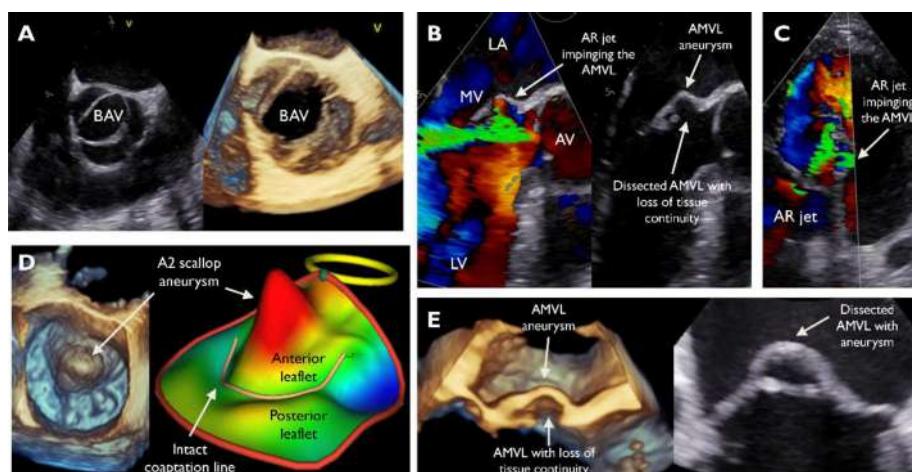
Transesophageal echocardiographic assessment of a bicuspid aortic valve. Mitral valve leaflet dissection and aneurysm secondary to bicuspid aortic valve regurgitation.
